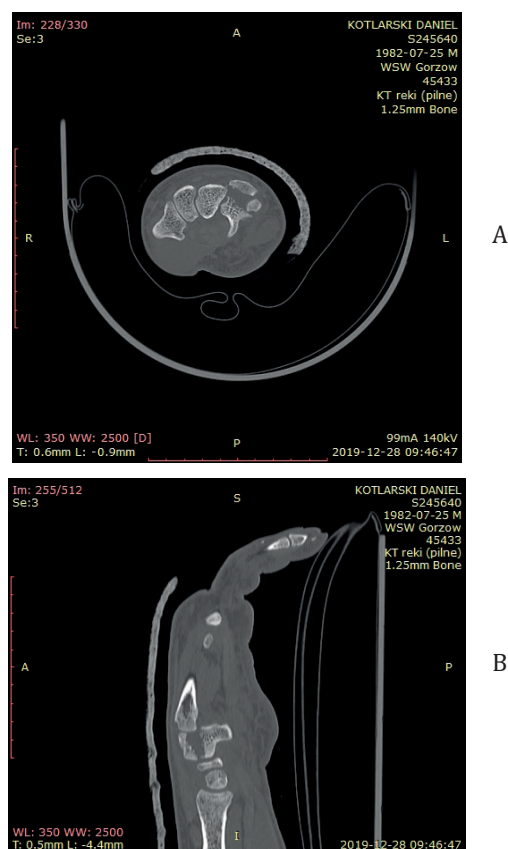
Computed tomography scan (A – coronal; B – sagittal) showing a fracture in the body of the hamate bone with dislocation
